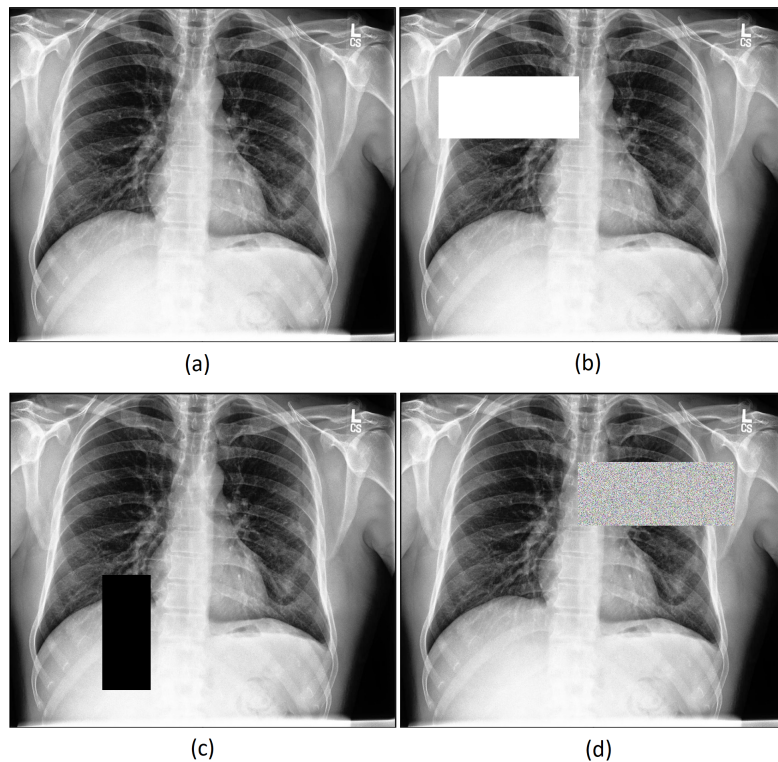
Example of random erasing transformation applied to chest x-ray image from CheXpert [53]. Respectively: (a) original image (b) white erasing value (c) black erasing value (d) random erasing value
